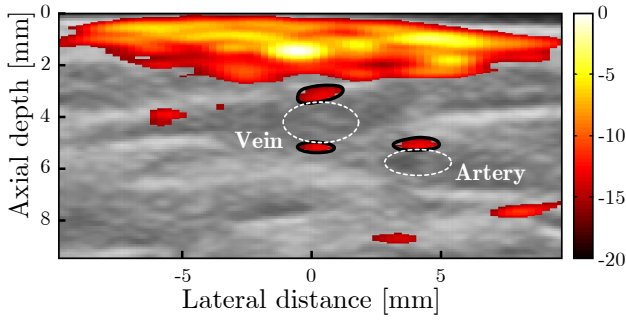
Photoacoustic (PA) image of the second author's inner elbow overlaid on a gray-scale B-mode image. The image is displayed on a normalised logarithmic scale with a dynamic range of 20 dB. The approximate locations of an artery and a vein (confirmed using colour Doppler in unreported experiments) are indicated by white ellipses, and the corresponding regions of interest used to measure the PA spectra are shown by the solid black outlines.
